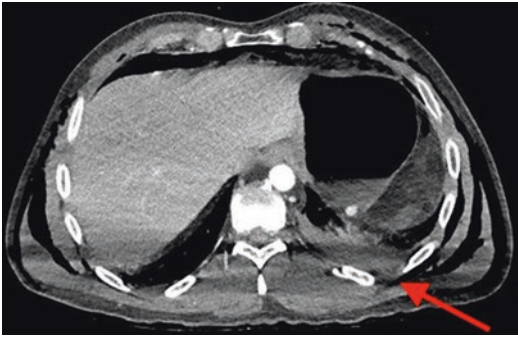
Axial plane CT image of a high density left sided haemothorax (red arrow)
